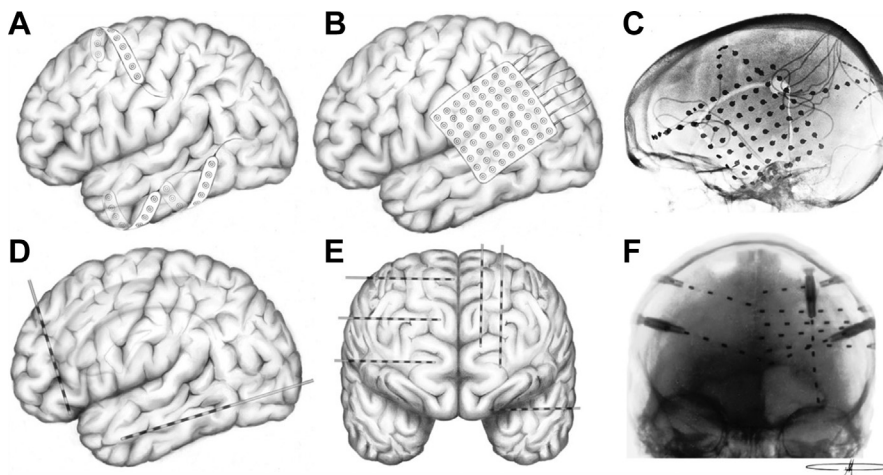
Types and possible positions of intracranial electrodes. (A) Lateral brain view of 9-contacts subdural electrodes in subtemporal and frontal structures. (B) Lateral view of a 64-contact mat over the parietoposterior temporal region. (C) Lateral radiograph from a patient with a 64-contact mat and four 8-contact subdural electrodes. (D) Lateral view with depth electrodes located in orbitofrontal cortex, and 1 electrode at the hippocampus (posterior approach). (E) Anterior posterior view with depth electrodes over frontal and temporal structures (lateral approach). (F) Anterior posterior radiograph from a patient with depth electrodes in frontal structures. (Courtesy of David Martín López, MD, PhD, King's College London, UK.)
